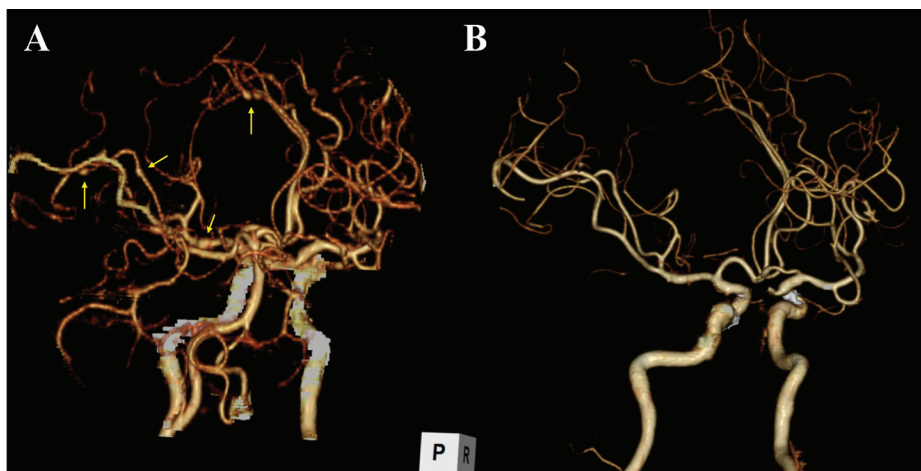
3-D CTA of cerebral arteries. (A) 3-D CTA shows multiple aneurysms (arrows) in cerebral arteries before treatment. (B) The aneurysms disappeared after 1-year treatment. CTA: computed tomographic angiography; P: posterior; R: right.
